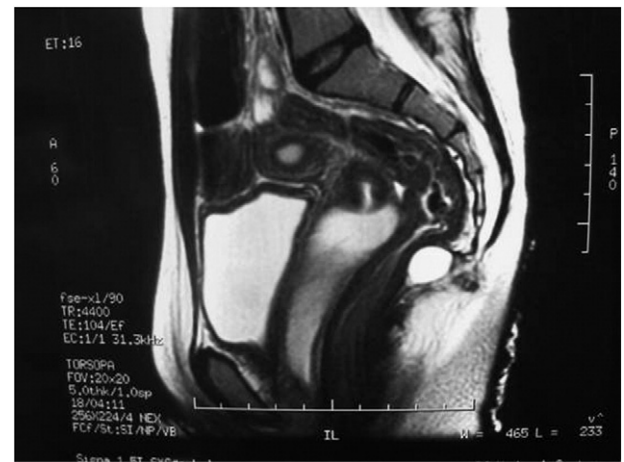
Magnetic resonance imaging revealing the presence of a rectal duplication.
